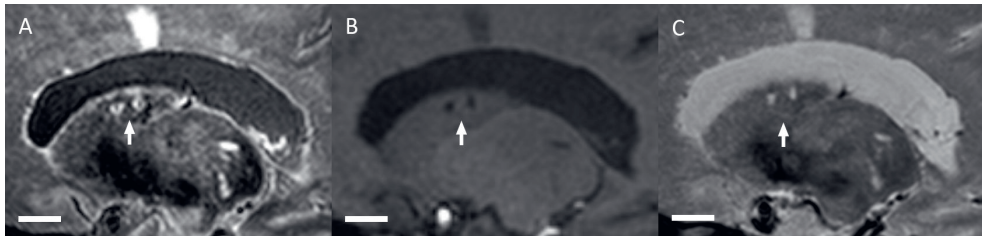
Two cavitated small infarcts (arrow) in the body of the left caudate nucleus in a 67-year old female shown on sagittal FLAIR (A), T1-weighted (B) and T2-weighted images (C) of the 7T MRI scan. These lesions are hypointense with a hyperintense rim on the FLAIR image, hypointense on the T1-weighted image and hyperintense on the T2-weighted image. Scale bar indicates 10 mm.
